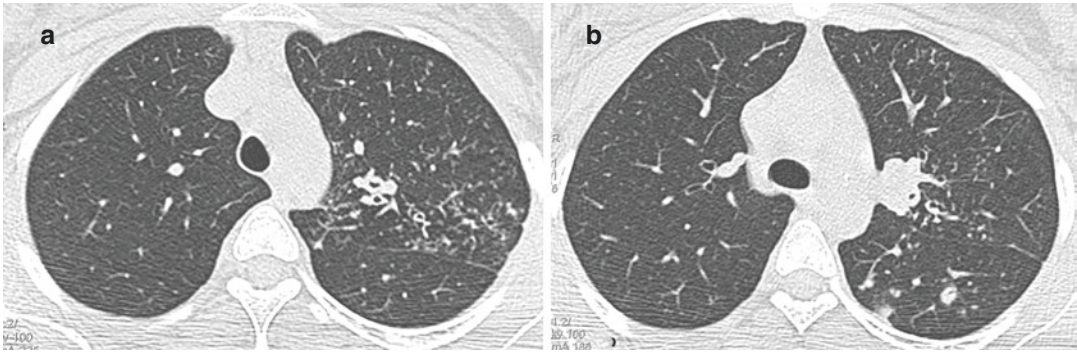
Paucibacillary tuberculosis in an 18-year-old patient who presented with chronic cough. (a and b) Axial CT images show micronodules and nodules of the left upper and lower lobes
